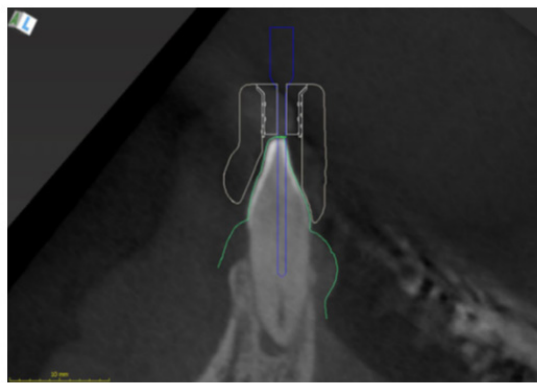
Virtual copy of drill is placed in such a way that the tip touches the radiographically visible part of the calcified root canal.
